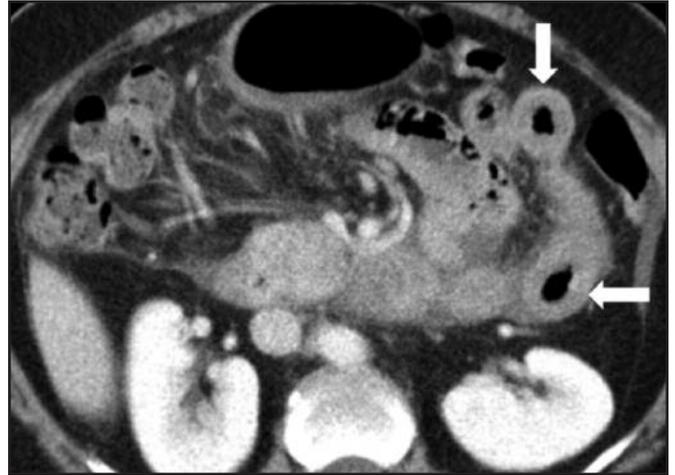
Axial section from a Computed Tomography of the abdomen performed with intravenous contrast medium showing concentric wall thickening of a segment of the jejunum (white arrows), a relatively common positive radiological finding in our series of patients with EG.
